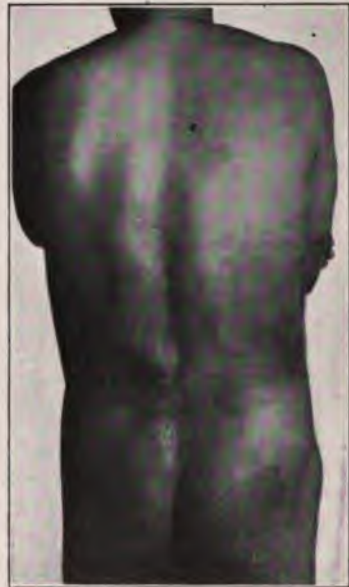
Same patient shown in Fig. 133, after universal roentgenization.
